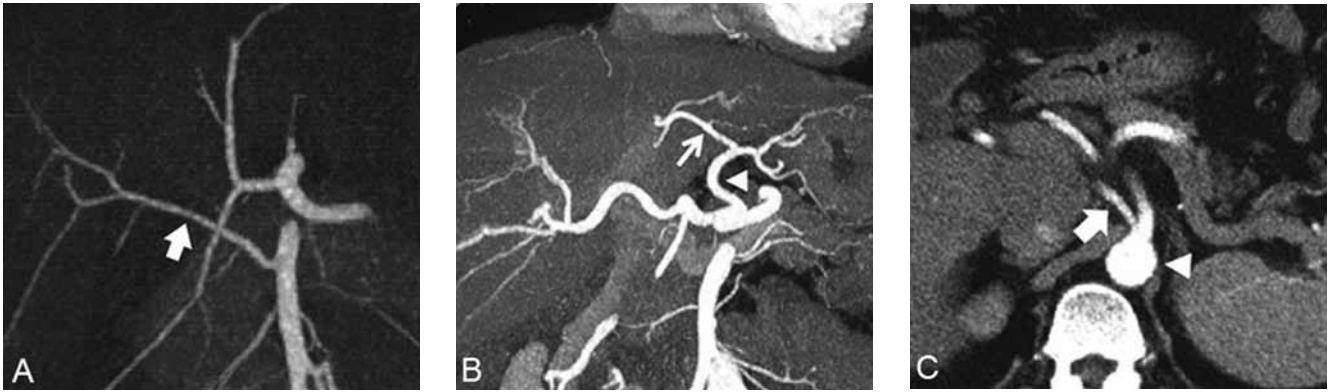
A. Common anatomical variants of the hepatic artery. Coronal MIP images of the right hepatic artery (arrow) originating from superior mesenteric artery. B. Coronal MIP images show the left hepatic artery (arrow) originating from the left gastric artery (arrowhead). C. Axial CT images showing the hepatic artery (arrow) originating directly from abdominal aorta (arrowhead).
